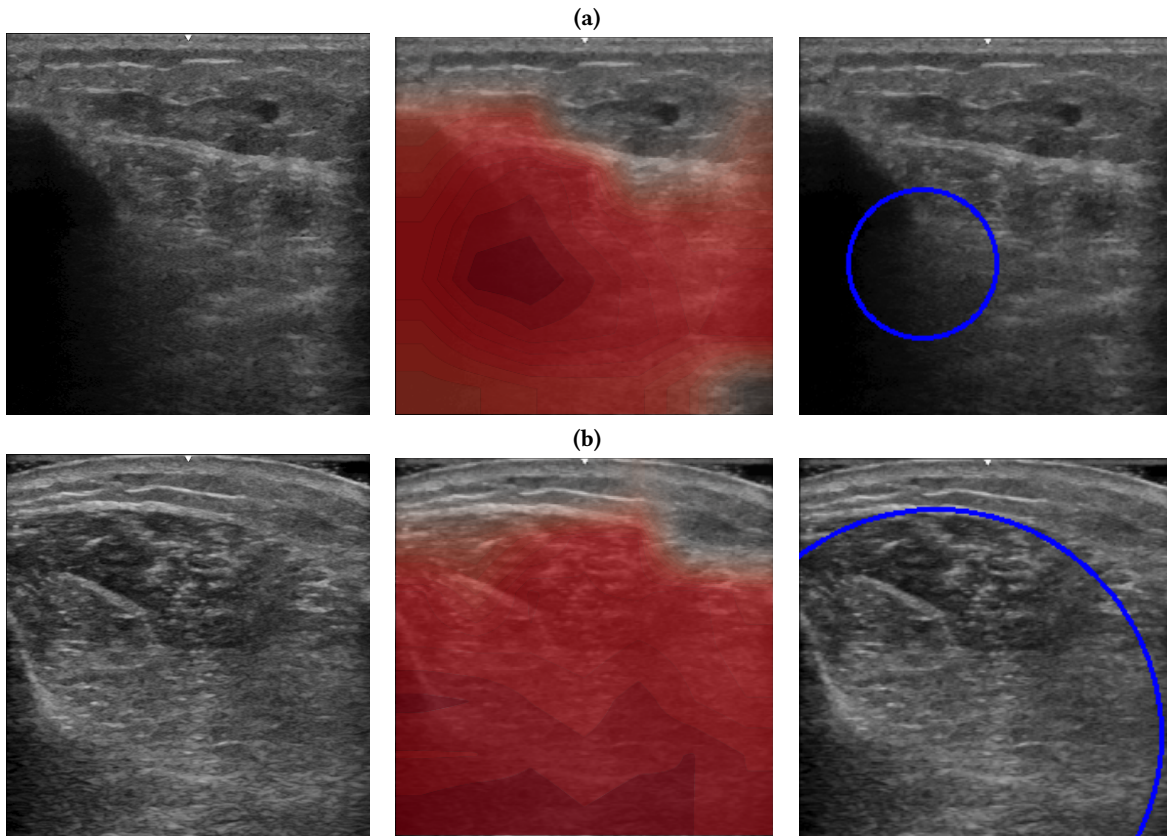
Plots of Grad-CAM-Based Feature Labeling for the Region of Interest (ROI) in Ultrasound Images: Panel (a) displays ultrasound images of a patient diagnosed with Inclusion Body Myositis (IBM), while Panel (b) showcases ultrasound images from a healthy individual for comparison. Each panel presents the images in a sequence from left to right: the original image, the heatmap overlay, and the circular labels.
